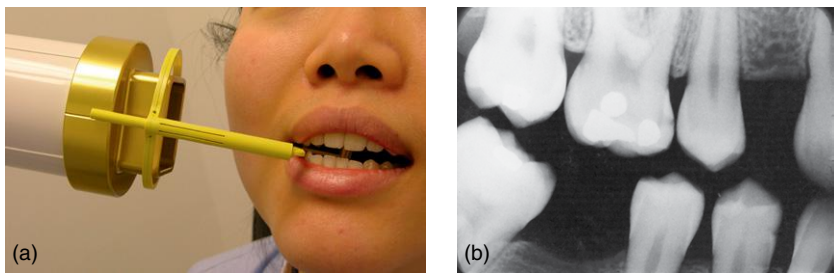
(a) A bitewing radiograph is being taken. The film is held lingually by a film holder and the patient closes together on a part of this holder. A beam-aiming device (the yellow arm) helps the operator position the tube so that the beam is directed at right angles to the film. (b) A bitewing radiograph showing caries in enamel and dentine on the mesial aspect of the first molar. A lesion is also visible on the mesial aspect of the lower first premolar.
